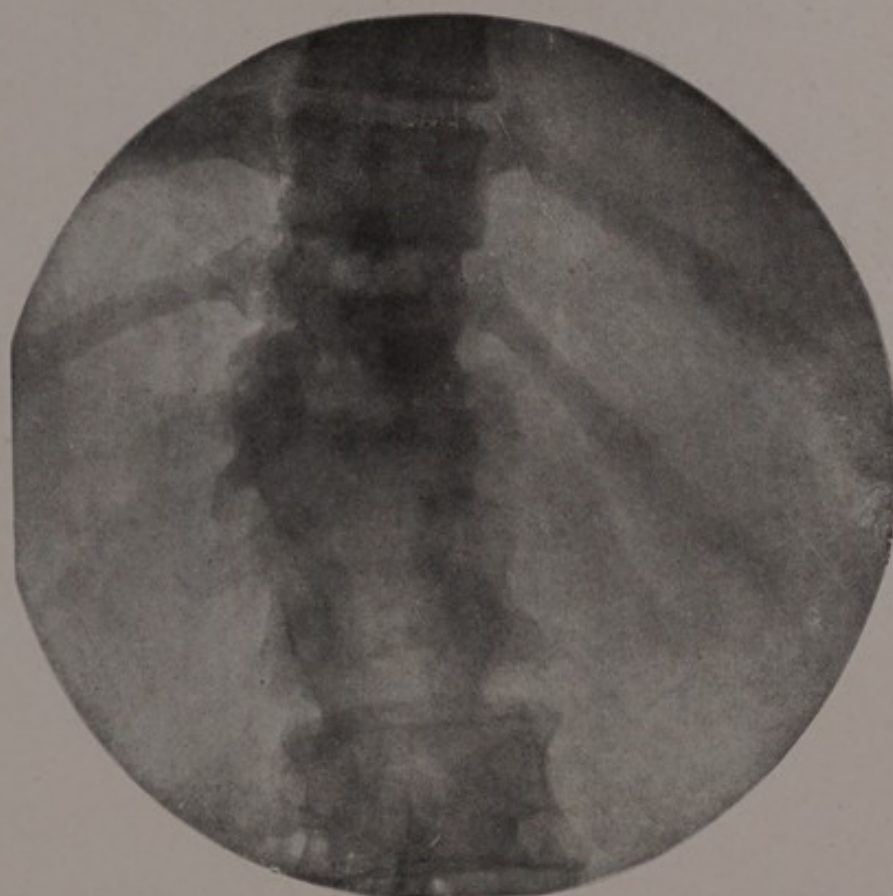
X-ray of fracture of the first and second lumbar vertebrae after decompressive laminectomy (N. Y. Neurological Institute).
